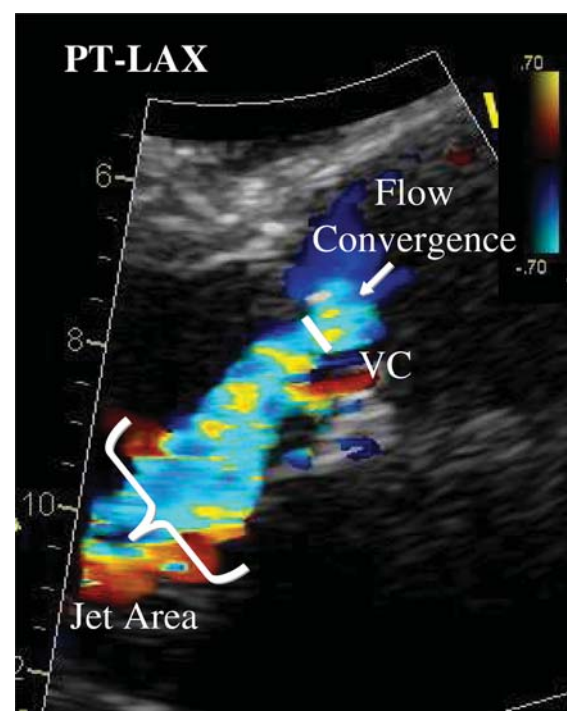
Semi-quantitative assessment of aortic regurgitation severity using the vena contracta (VC) width. The three components of the regurgitant jet (flow convergence zone, vena contracta, jet turbulence) are obtained. PT-LAX, parasternal long-axis view.
